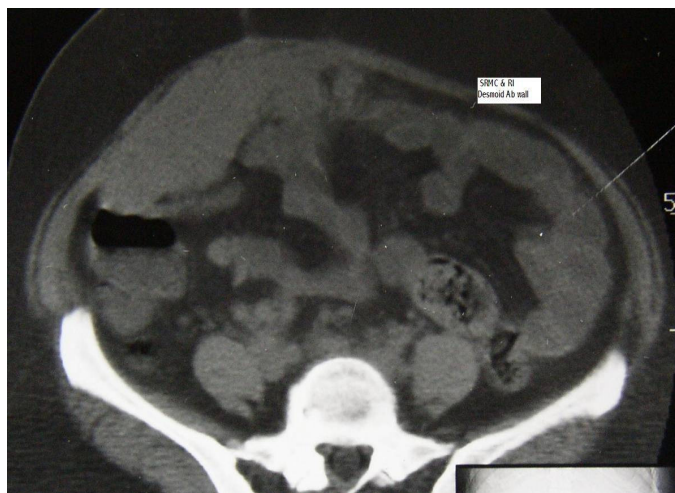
CT shows the mass arising from the right parietal wall of the abdomen.
